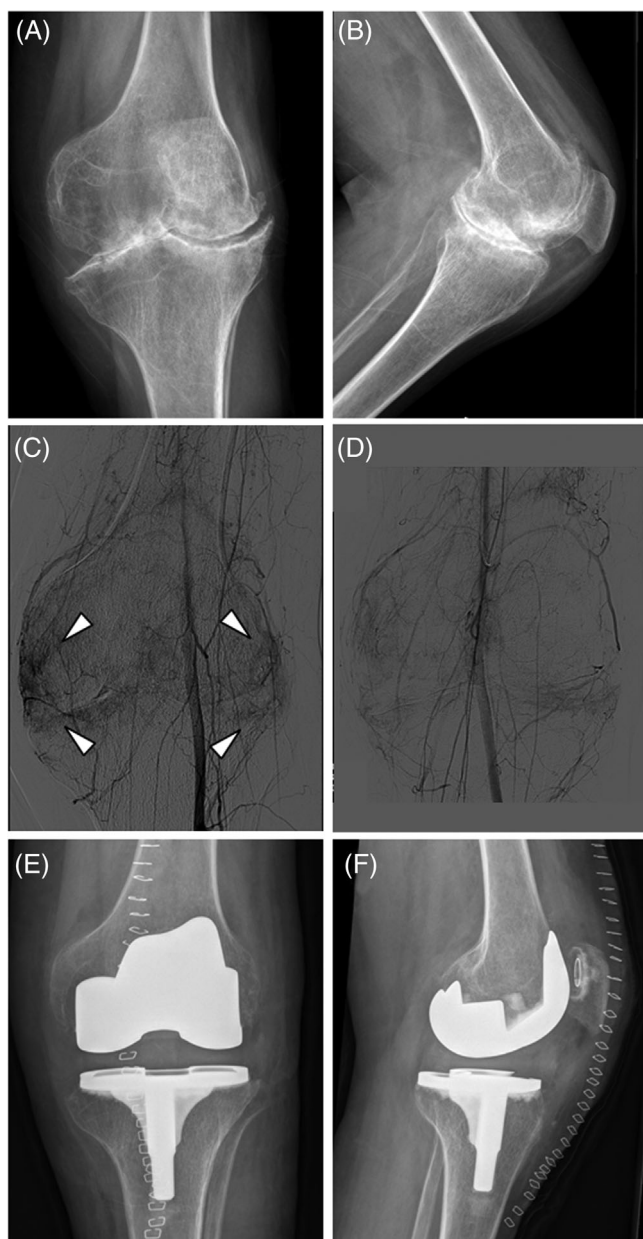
Pre-operative genicular artery embolization in the left knee with synovial hyperaemia. (A,B) Pre-operative radiographs of the left knee with severe haemophilic arthropathy. (C) Angiography pre-embolization with synovial hyperaemia (arrowheads). (D) Angiography post-embolization with particles showing a decrease of synovial hyperaemia. (E,F) Postoperative radiographs of the left knee.
